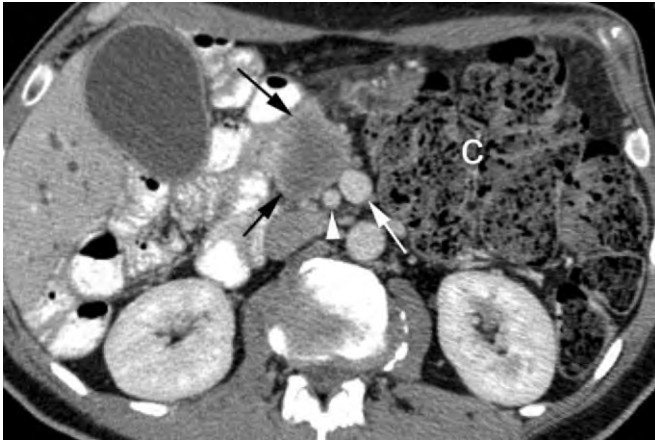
Contrast-enhanced CT image of a 53-year-old man with pancreatic cancer demonstrating a pancreatic tumor (*black arrows*) abutting the superior mesenteric vein (*white arrow*) and separated from the superior mesenteric artery (*white arrowhead*) by an intact fat plane. This patient has malrotation of the bowel; complete nonrotation of the midgut with nonrotation of both the duodenojejunal limb and the cecocolic limb. The superior mesenteric vein is located to the patient's left of the superior mesenteric artery. Note that the colon (C) is located in the left side of the abdomen consistent with malrotation.
